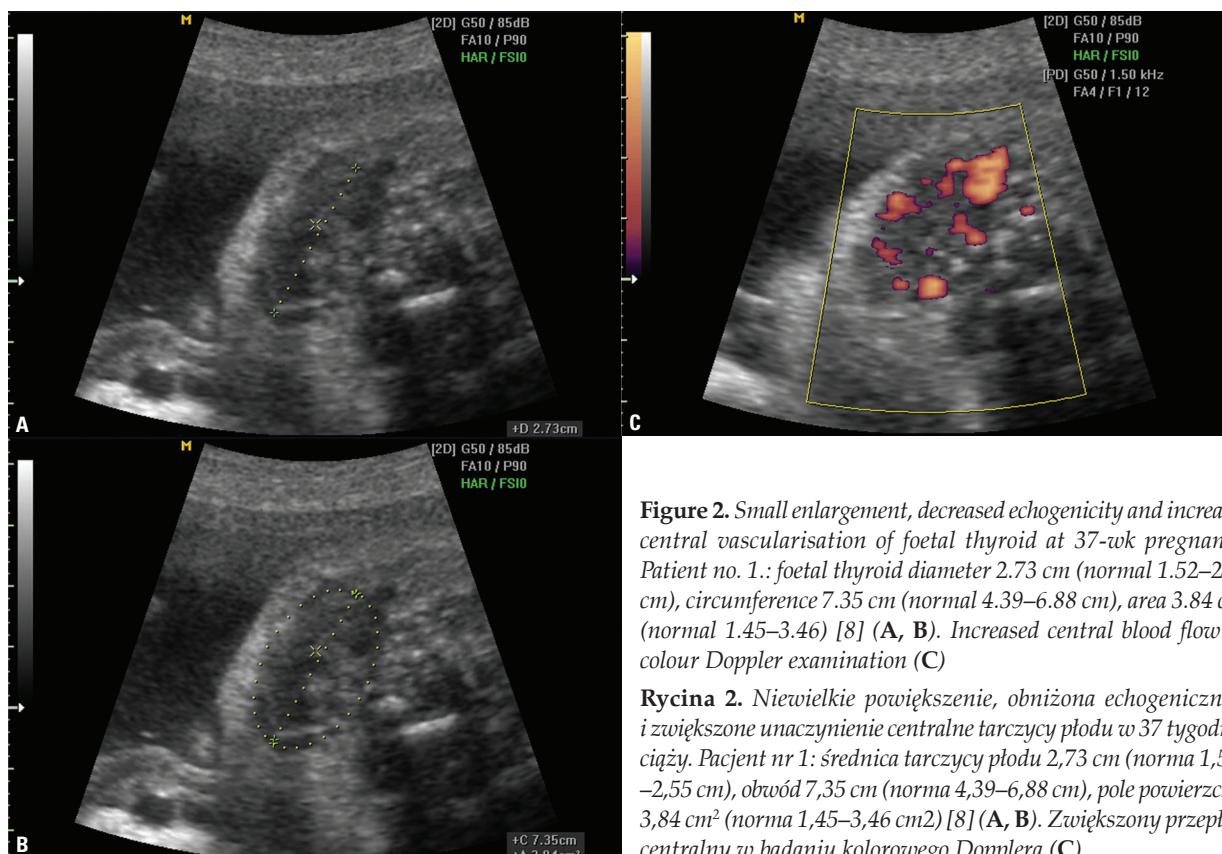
Small enlargement, decreased echogenicity and increased central vascularisation of foetal thyroid at 37-wk pregnancy. Patient no. 1.: foetal thyroid diameter 2.73 cm (normal 1.52–2.55 cm), circumference 7.35 cm (normal 4.39–6.88 cm), area 3.84 cm² (normal 1.45–3.46) [8] (A, B). Increased central blood flow on colour Doppler examination (C)
